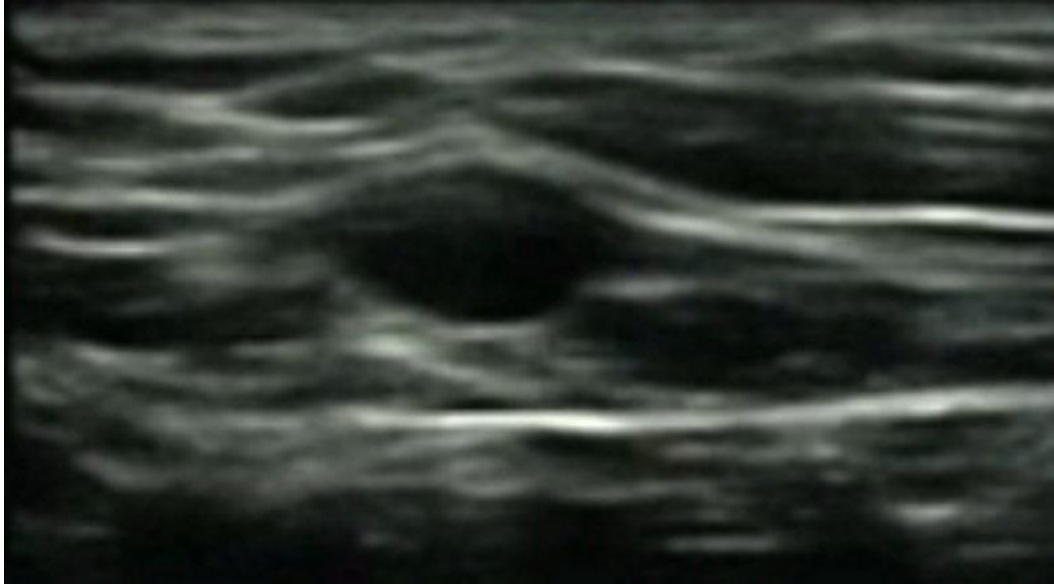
Ultrasound of the basilic vein. Case courtesy of David Carroll, Radiopaedia.org, rID: 64446.
